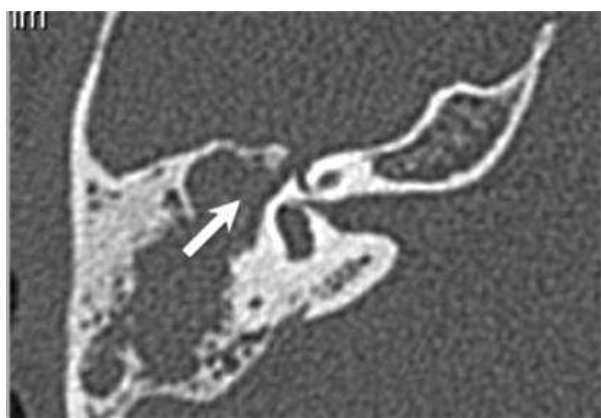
(Axial HRCT. Right-sided dehiscence of lateral semicircular canal (arrow).
